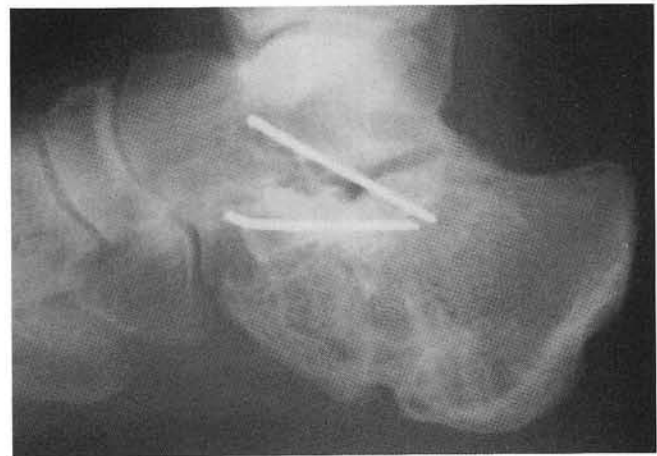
Lateral radiograph of the rearfoot at 11 months post injury.
